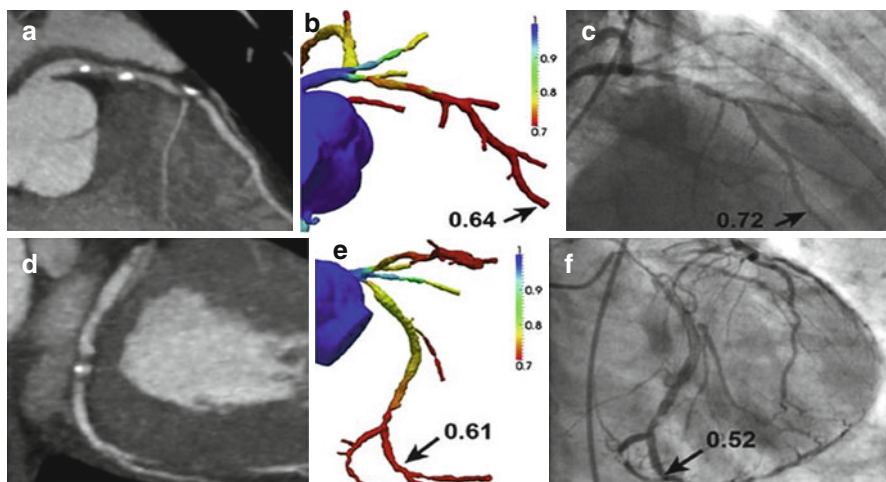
(a) CTA demonstrating stenosis in the LAD. (b) FFRCTA demonstrates ischemia in the LAD, with a computed value of 0.64. (c) ICA with FFR also demonstrates ischemia in the LAD, with a measured value of 0.72. (d) CTA demonstrating stenosis in the LCx. (e) FFRCTA demonstrates ischemia in the LCx, with a computed value of 0.61. (f) ICA with FFR also demonstrates ischemia in the LCx, with a measured value of 0.52 (Adapted with permission from Taylor et al. [13])
